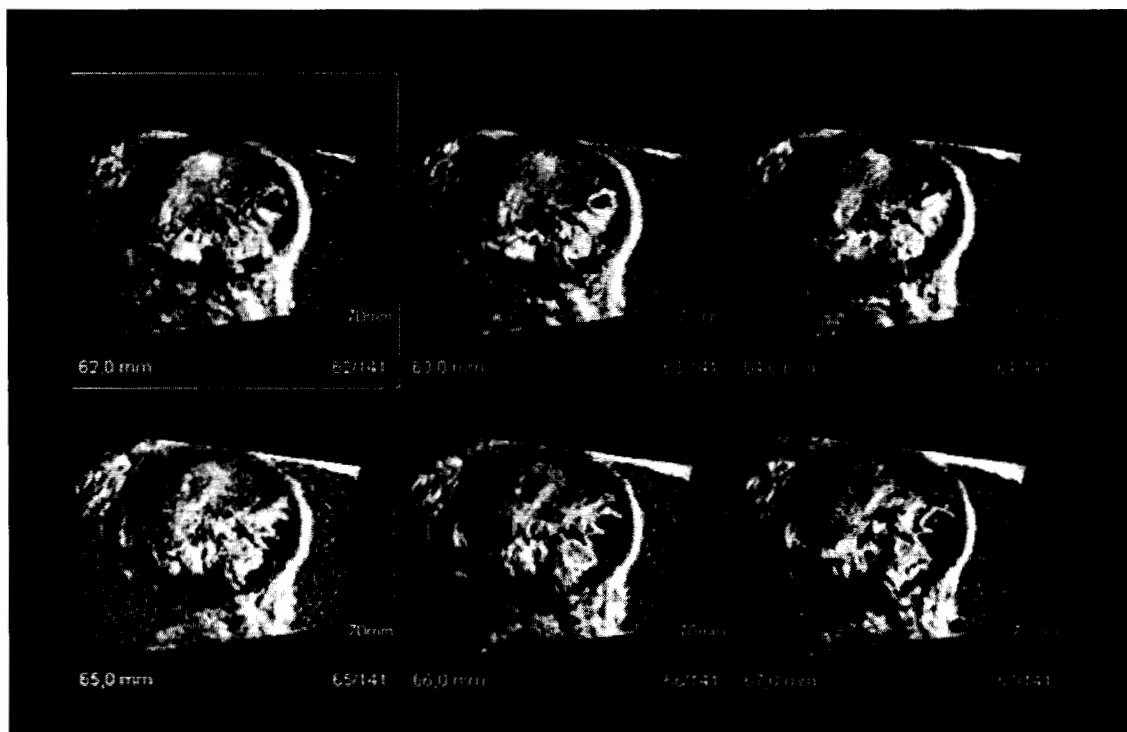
Ultrasound images.
